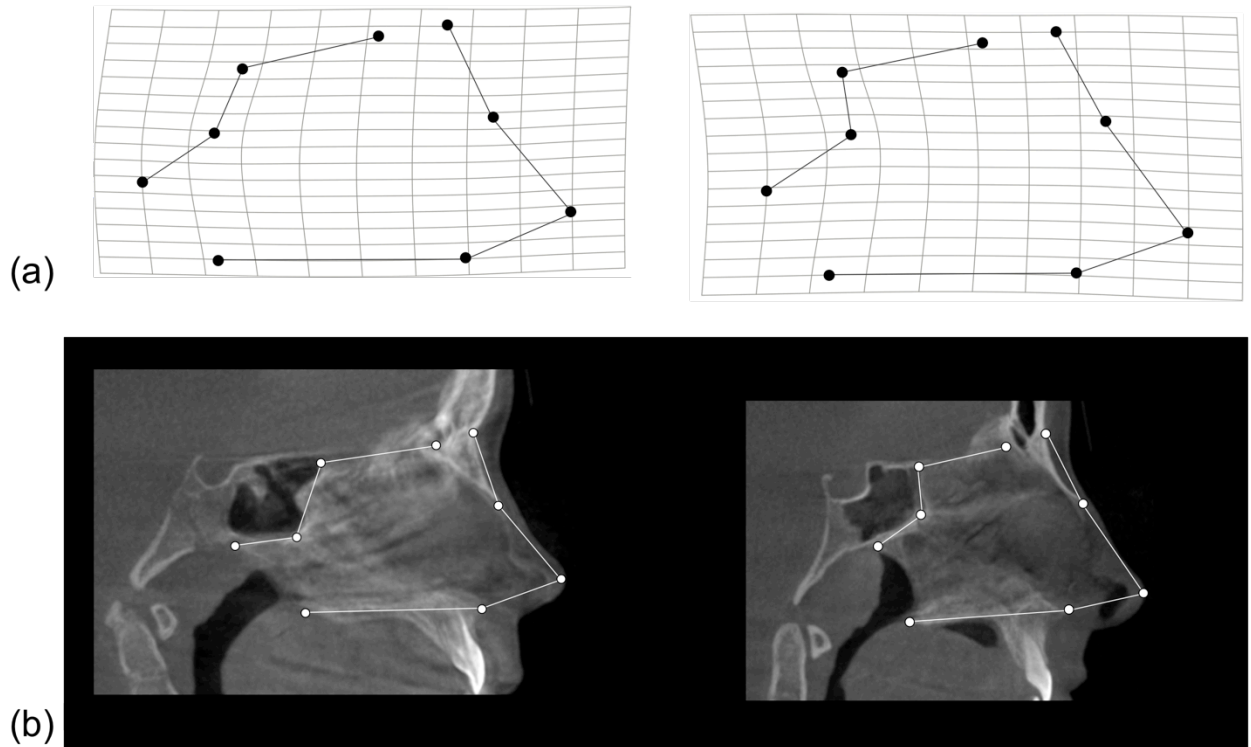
Shape variation correlated with nasal septal deviation. (a) Thin plate splines and wireframe models representing the range of shape variation correlated with nasal septal deviation. The spline and wireframe on the left represents shape variation associated with no septal deviation, while the spline and wireframe on the right represents variation associated with greater levels of septal deviation. (b) Midsagittal cone beam computed tomography images of individuals spanning the range of septal deviation values from small (left) to larger (right).
